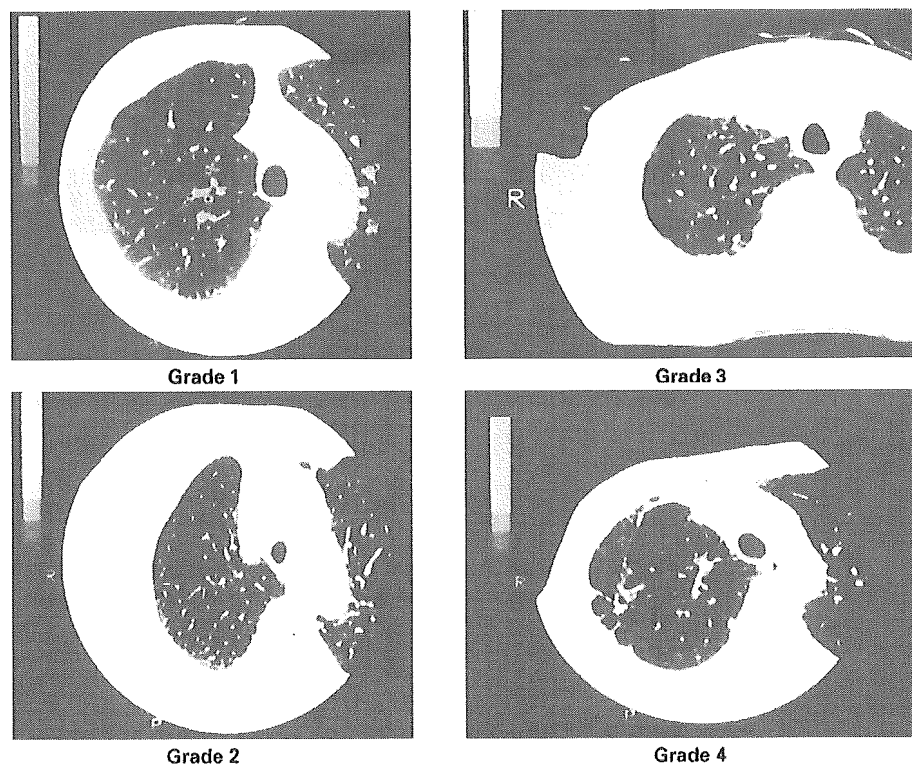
Grading of CT in emphysematous patients. Emphysematous change became severe from grade 1 to 4. Gradings were divided by the distribution of LAA and their sizes. This grading was done according to a previously described method [12].
